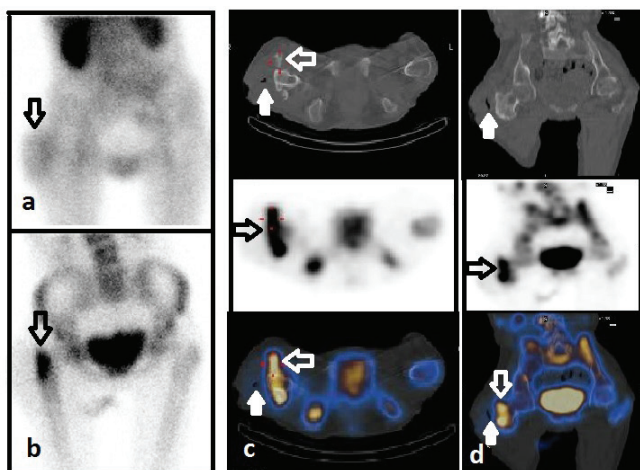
A 22-year-old woman who had right hemiplegia and was suspected as having osteomyelitis in the right upper femur. (A) Blood pool anterior image shows heterogeneous hyperemia in the soft tissues just lateral to the trochanter major (arrows). (B) The intense osteoblastic uptake is seen on trochanteric regions in the anterior late static image. (C) Axial, (D) coronal single photon emission computed tomography (SPECT)/CT images show fistula tract in the soft tissue (white arrows). Fusion images show that radiotracer uptake around the trochanter major is associated with the bone structures within soft tissue (arrows). The findings of SPECT/computed tomography (CT) are described as heterotopic ossification and soft tissue infection. This diagnosis is confirmed by CT and pathology
